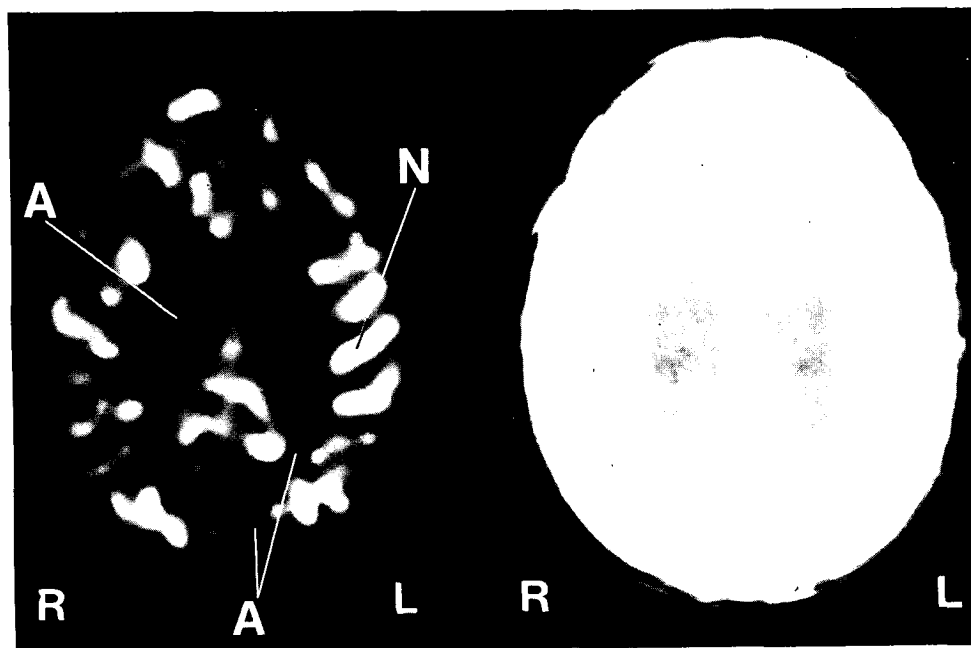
A standard CT cut of the brain of RJ is shown on the right, with a corresponding xenon-enhanced image on the left (Day 5 after the accident). The standard CT image shows no abnormality, whereas areas of abnormally low rCBF (A) are clearly seen on the xenon-enhanced image. These areas correspond to regions of edema seen in the MRI scan (Fig. 3). An area of normal blood flow is indicated (N).
